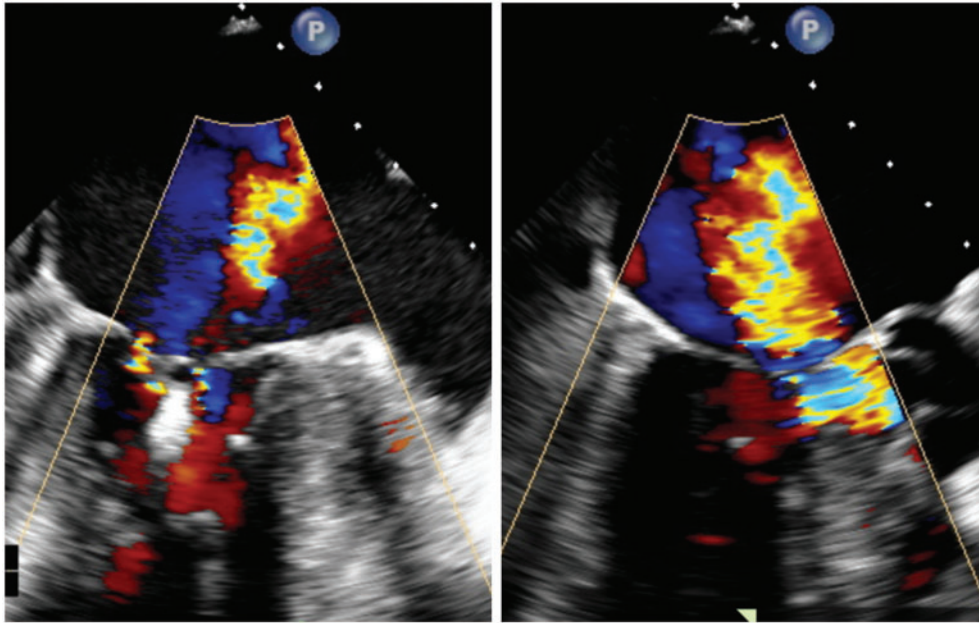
First clip was placed centrally over the flail segment with reduction of the mitral regurgitation grade from 4+ to 2+. Transoesophageal echocardiographic views showing residual posteriorly directed mitral regurgitation at the A1 segment, lateral to the first clip, and was systolic anterior motion-related.
